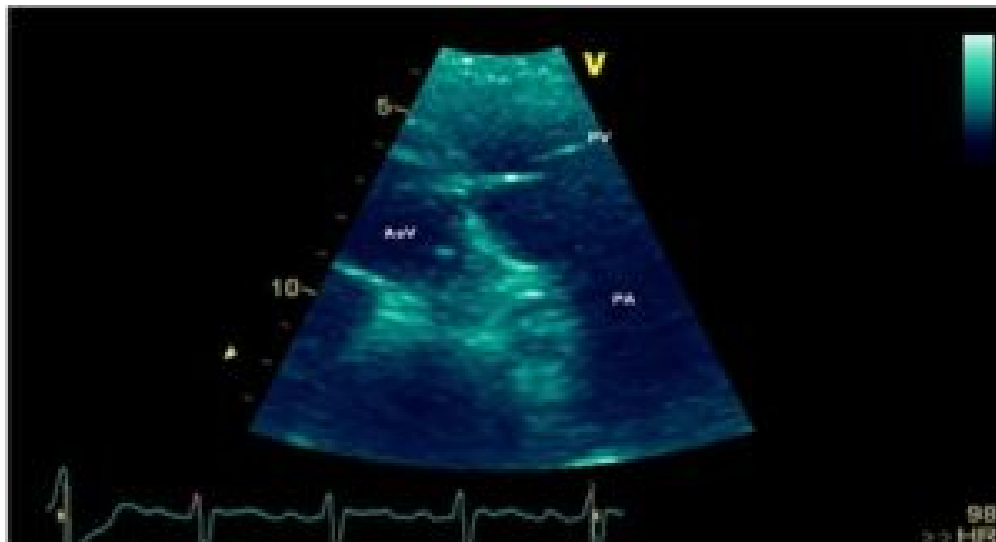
Pulmonary valve at discharge using transthoracic echocardiogram, 4 weeks after empiric antibiotic therapy.¹
